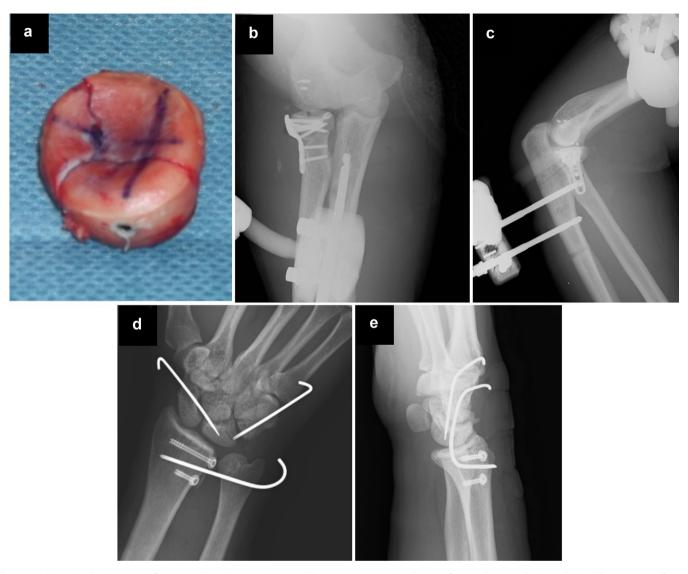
Radiographs after the internal fixation (11 days after injury), (a) On-table reconstruction with preliminary fixation, (b, c) ORIF for the radial head fracture, suture fixation for the coronoid fracture by lasso technique, medial and lateral collateral ligament repair were performed. (d, e) ORIF for the distal radius fracture, pinning for the unstable DRUJ, and pinning for the missed lunate instability were also performed. ORIF, open reduction and internal fixation; DRUJ, distal radioulnar joint.
